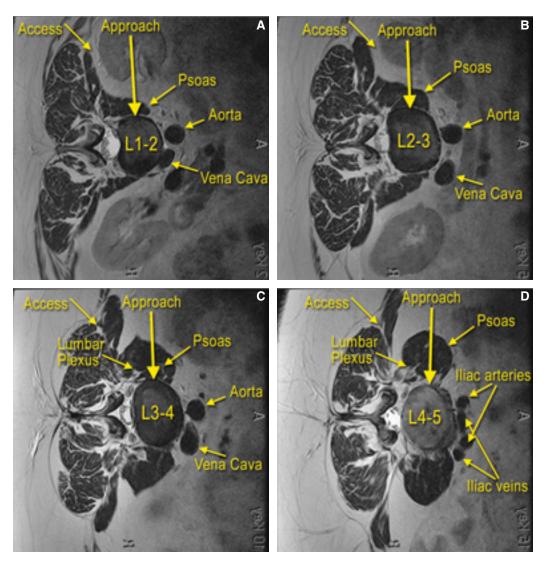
Lumbar anatomy as it relates to the lateral transpsoas approach for interbody fusion on axial MRI from L1-2 to L4-5. Note the progressively increasing psoas major diameter.
